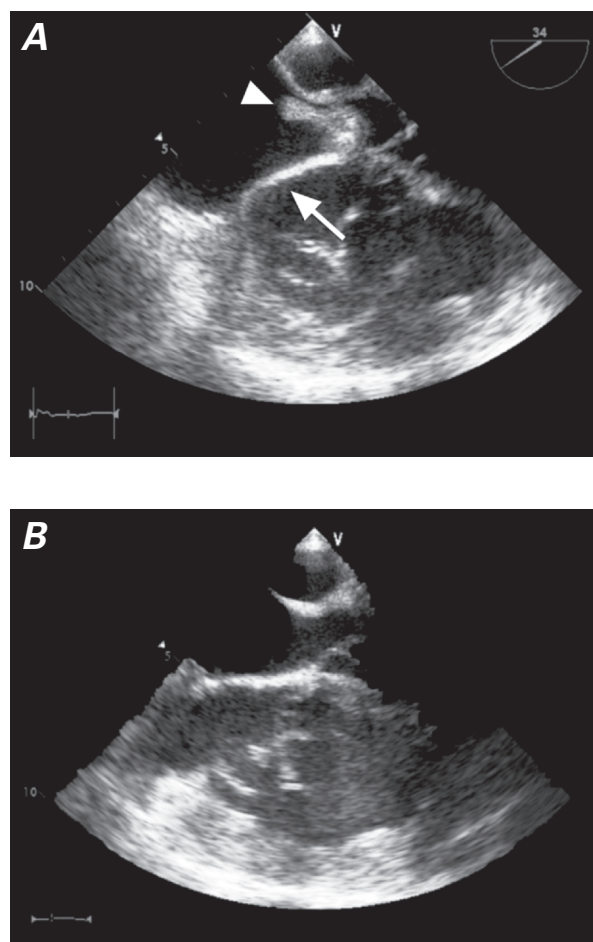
Transesophageal echocardiograms. A) A mass (arrowhead) obstructs the venous return of the systemic venous baffle (arrow). B) Appearance after removal of the mass.
